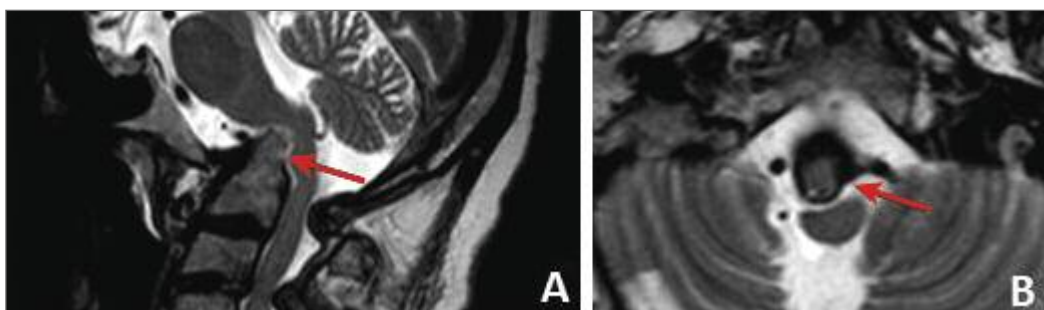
MRI: Sagittal T1 (Panel A) and axial T2 (Panel B) showing protrusion of the odontoid process at the posterior fossa with stenosis of the foramen magnum and significant medullary compression (red arrows)
